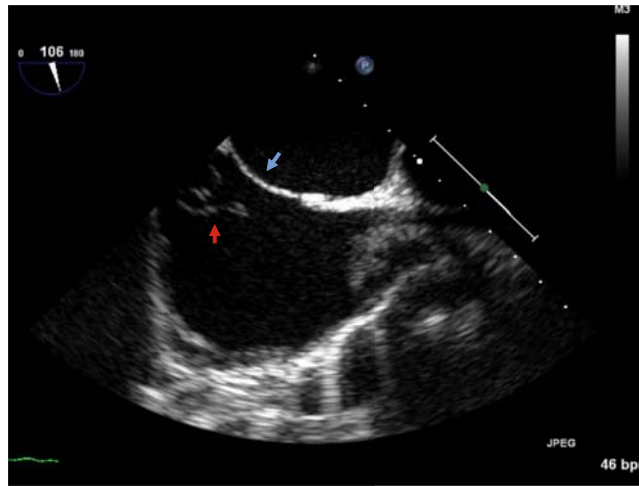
Bicaval view by transesophageal echocardiography showing an atrial septum that proved aneurysmal during motion (*blue arrow*) with the presence of a Chiari network (*red arrow*).
